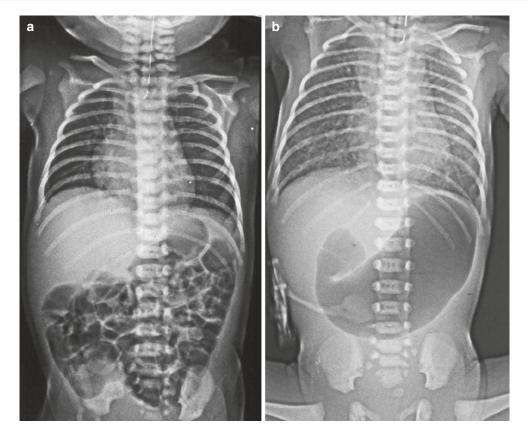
Pre-operative radiographs in babies with oesophageal atresia and tracheo-oesophageal fistula. The case on the right also had duodenal and ano-rectal atresias
